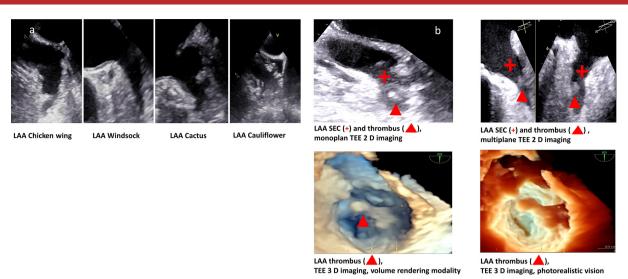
(a) Four different LAA types as shown by TEE from study patients. (b) LAA showing SEC and thrombus by 2D TEE (upper row) and 3D TEE (lower row) in study patients. 2D, two-dimensional; 3D, three-dimensional; LAA, left atrial appendage; SEC, spontaneous echo contrast; TEE, transoesophageal echocardiography.
